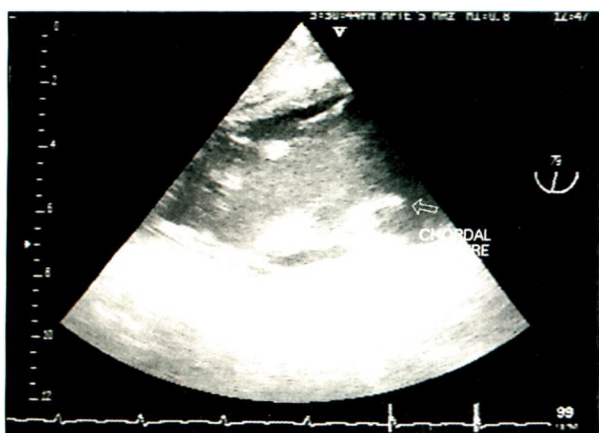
Papillary cordae rupture in apical four chamber view.
